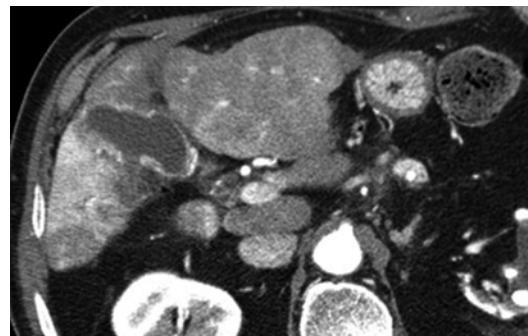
Post-radioembolization. Axial contrast-enhanced CT image during the arterial phase of a case of post-radioembolization cholecystitis, showing gallbladder wall thickening and irregularity, disruption of the gallbladder wall, and pericholecystic fat infiltration (Image courtesy of Frank H. Miller, Northwestern University Feinberg School of Medicine, Chicago, USA)
